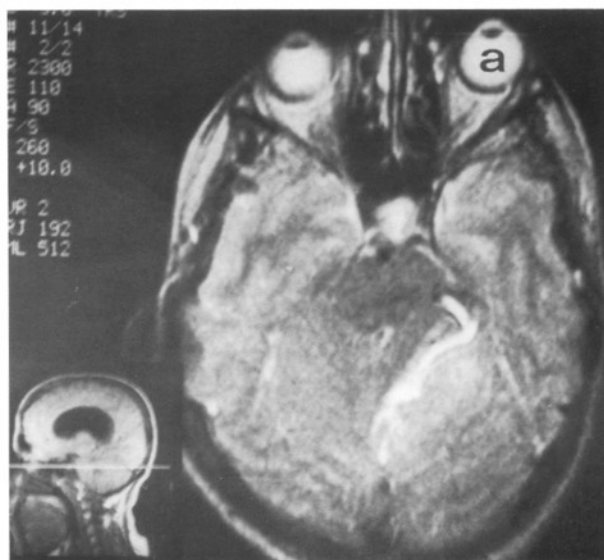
a and b. MRI shows a lesion on the left cerebellar hemisphere localized laterally, hyperintense non-contrast enhanced and compressing the upperbrain stem and the 4th ventricle; and in the ventromedial part of the lesion a dilated vascular structure, triventricular hydrocephaly, and syringomyelic cavity extending between C2-C3 level.
